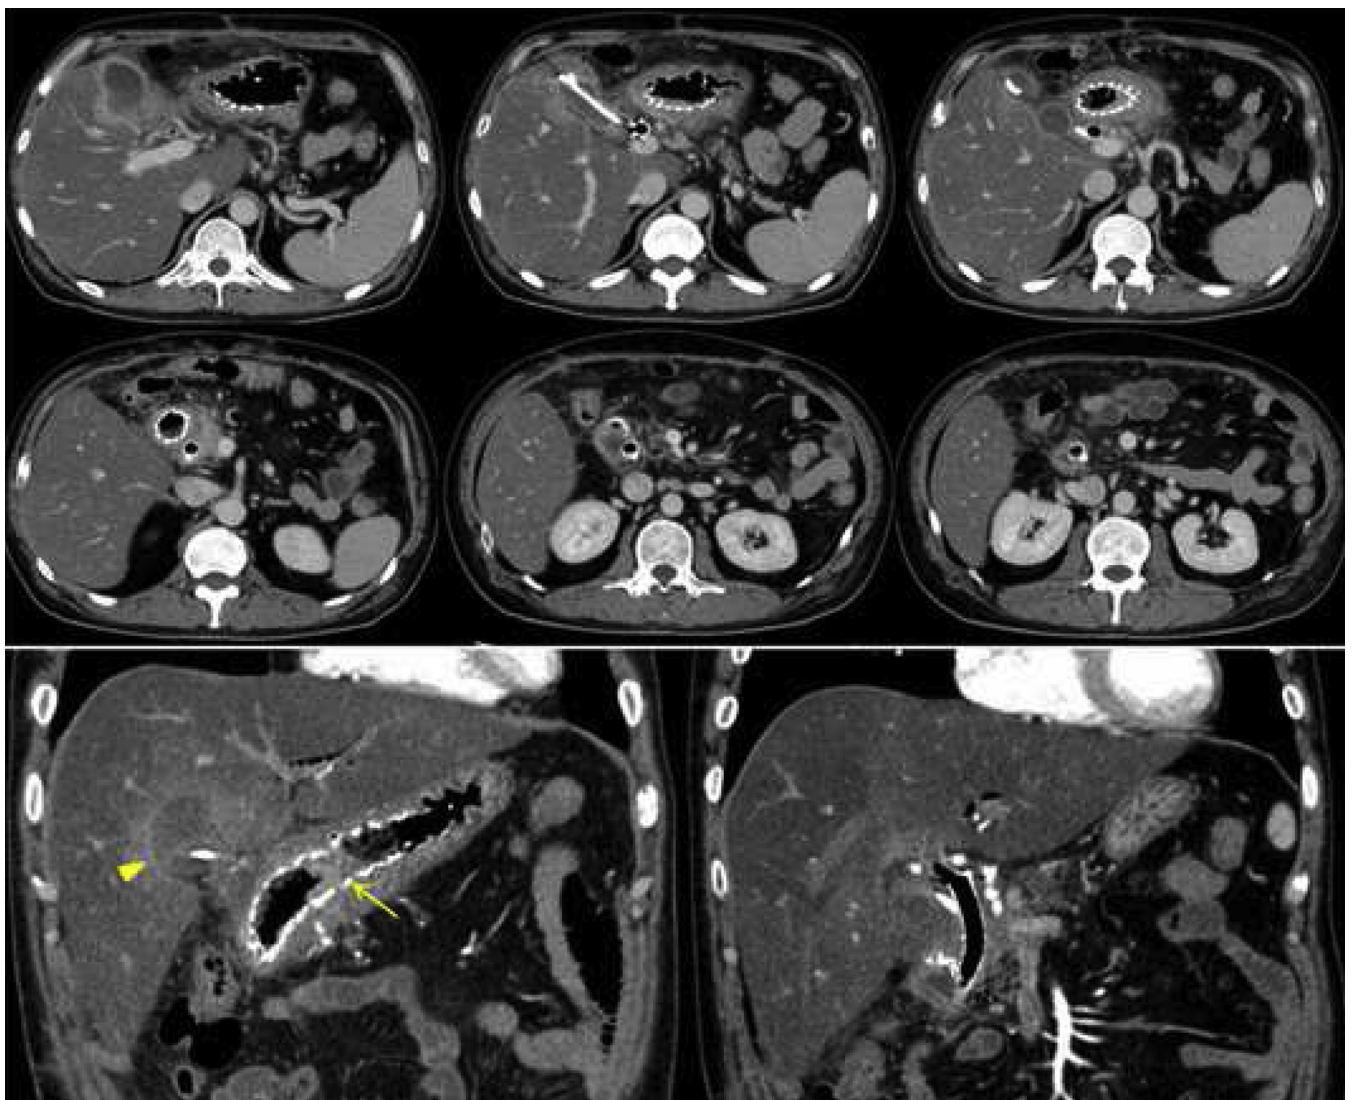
CT scan showing cholecystitis (*arrowhead*), suggesting gallbladder stent dysfunction. A biliary metallic stent and a gallbladder plastic stent had been transpapillary placed in a side-by-side fashion. The distal end of the duodenal stent was located proximal to the papilla, and tissue hyperplasia through the mesh was suspected at the midportion of the stent (*arrow*).
